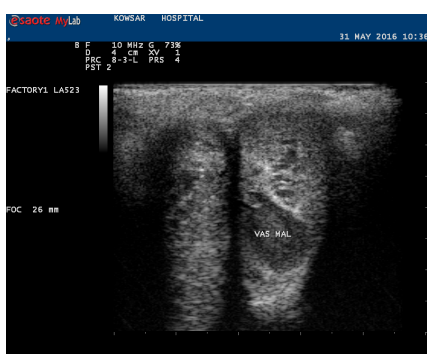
Gray scale ultrasound shows an irregular hypoechoic region secondary to distended lacunar spaces.
